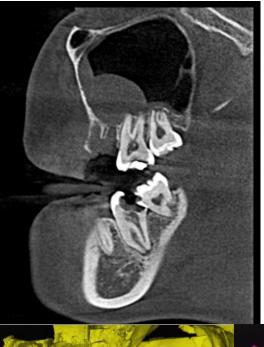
CBCT showing mandibular molars
